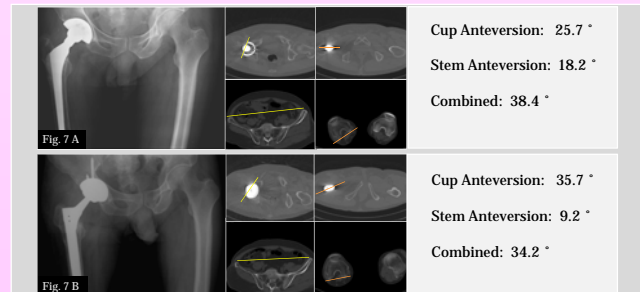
62-year-old male patient; Revision of both stem and cup Preoperative (A) and Postoperative (B) X-ray and CT
